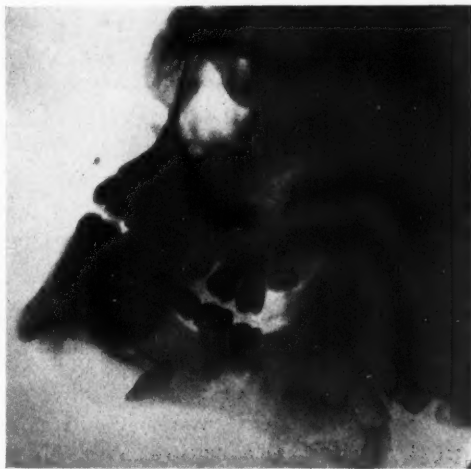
Roentgenogram of a dentigerous cyst showing a tooth lying within a central cavity. (Dr. Kahn's case.)
